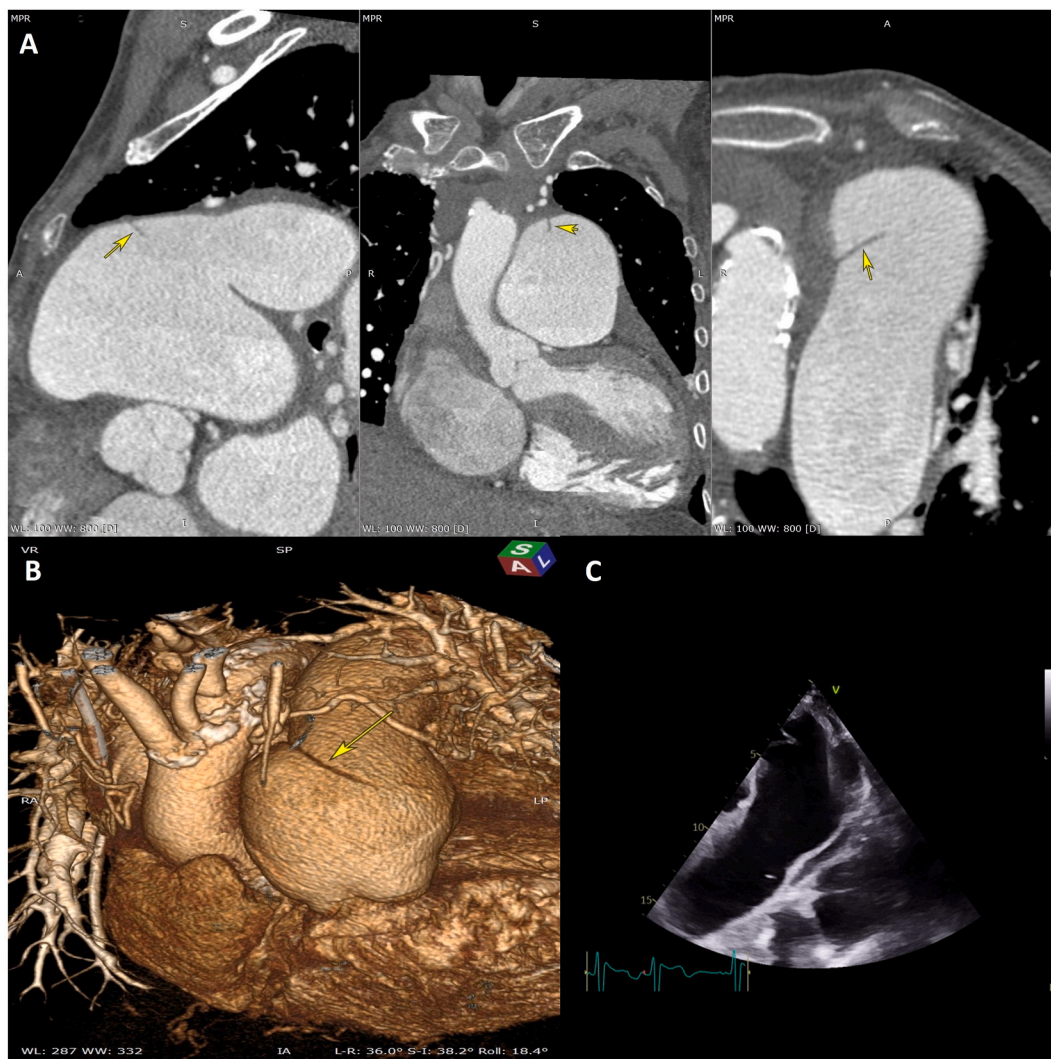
67 year-old woman with severe CTEPH and advanced right heart failure was admitted with sharp, tearing chest pain of abrupt onset. Non-invasive imaging with cardiac computed tomography (A, B) and transthoracic echocardiography (C) demonstrated a dissection of a dilated pulmonary artery. chronic thromboembolic pulmonary hypertension.
